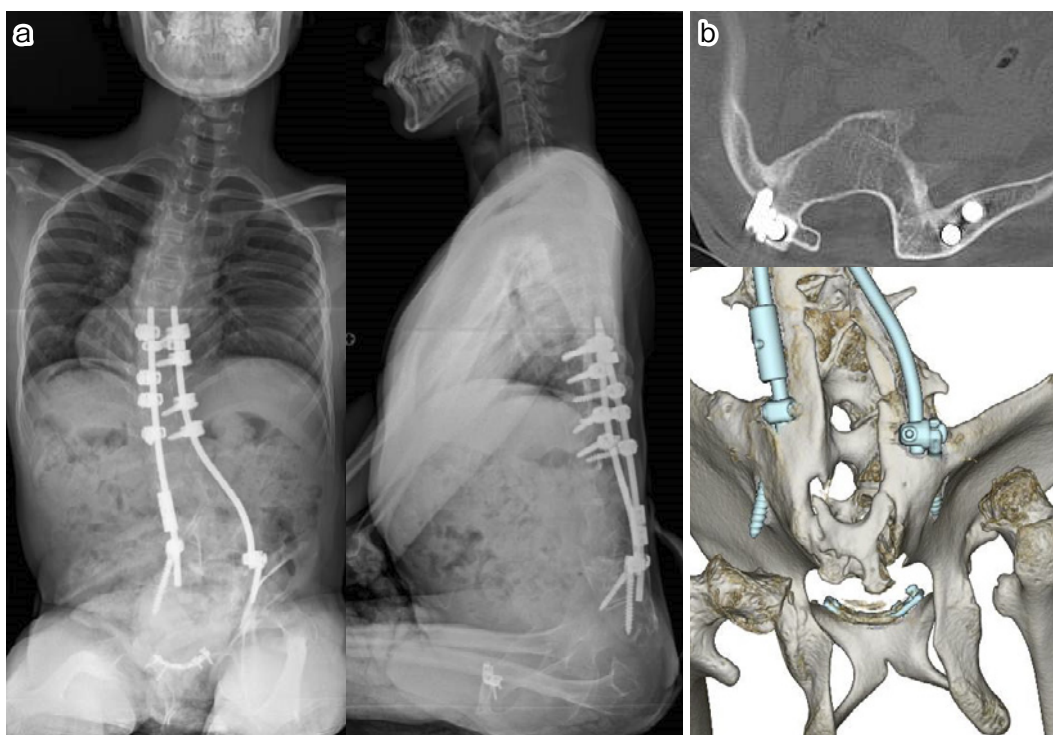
a: Plain X-ray images showing rigid fixation at the pubic symphysis combined with posterior fixation of the spinopelvic junction; b: CT images showing complete bone union at the spinopelvic junction.
